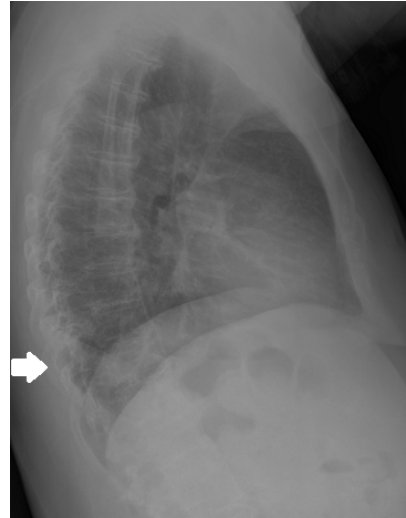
Lateral chest radiograph
